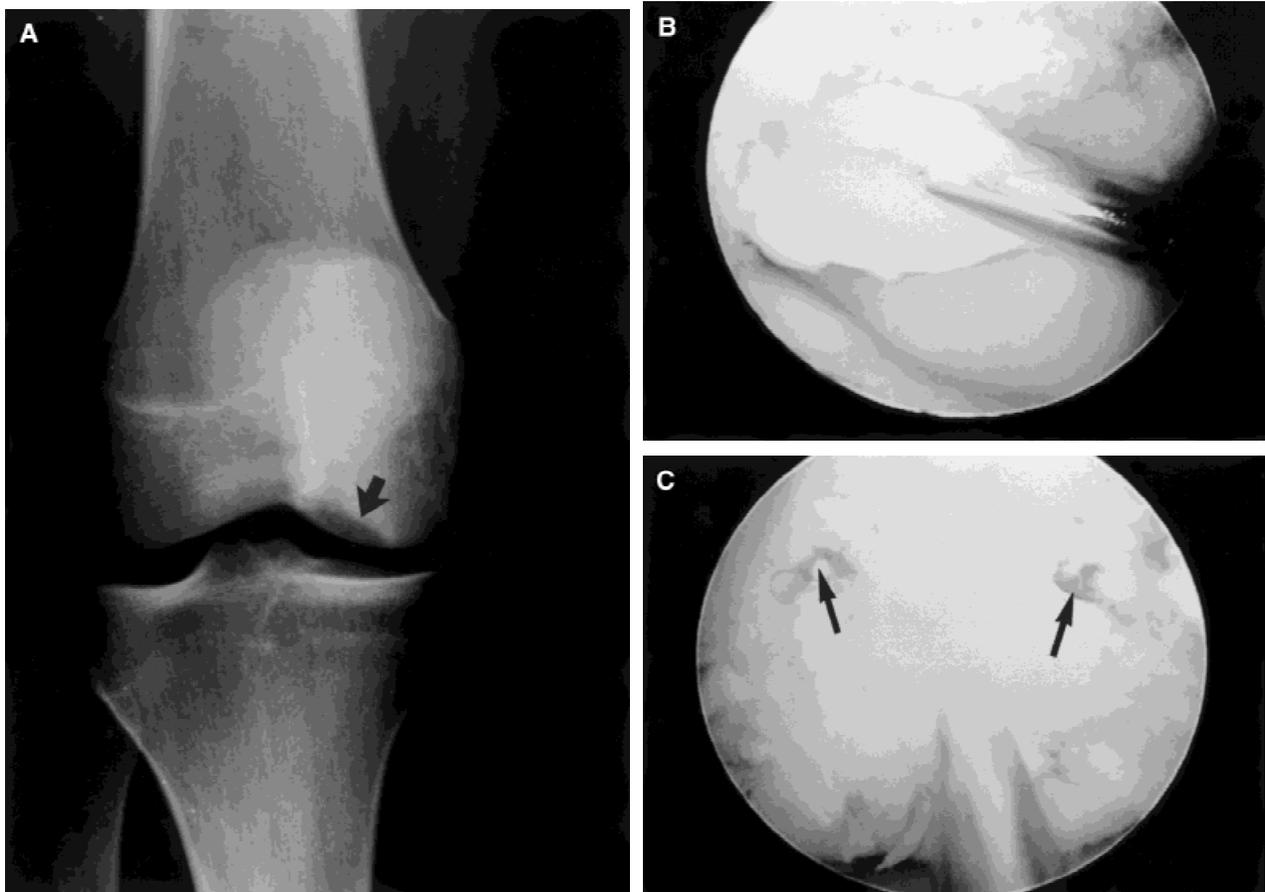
A 13-year-old female, who did not participate in any regular exercise program, presented to our emergency department with immediate knee pain and swelling after performing resistance exercise on a leg press machine. She could not ambulate without discomfort, and the knee was locked in flexion. On physical examination, she had marked effusion and anteromedial joint line tenderness. Stress testing revealed no pathologic laxity, but the Wilson test elicited pain in the area of the medial joint line. Full painless range of motion was present in her hips and uninvolved knee with no tenderness and normal strength throughout. (A) Plain radiographs revealed an OCD lesion of the medial femoral condyle and closed physes. Based on her skeletal maturity and severity of symptoms, surgery was performed. (B) Multiple loose bodies were removed, and (C) antegrade drilling was performed in an attempt to fill in the defect with reparative cartilage. Recruitment of pluripotential cells from the marrow is demonstrated by the bleeding (arrows). Three months after the operation, the patient was able to perform her activities of daily living symptom-free.
